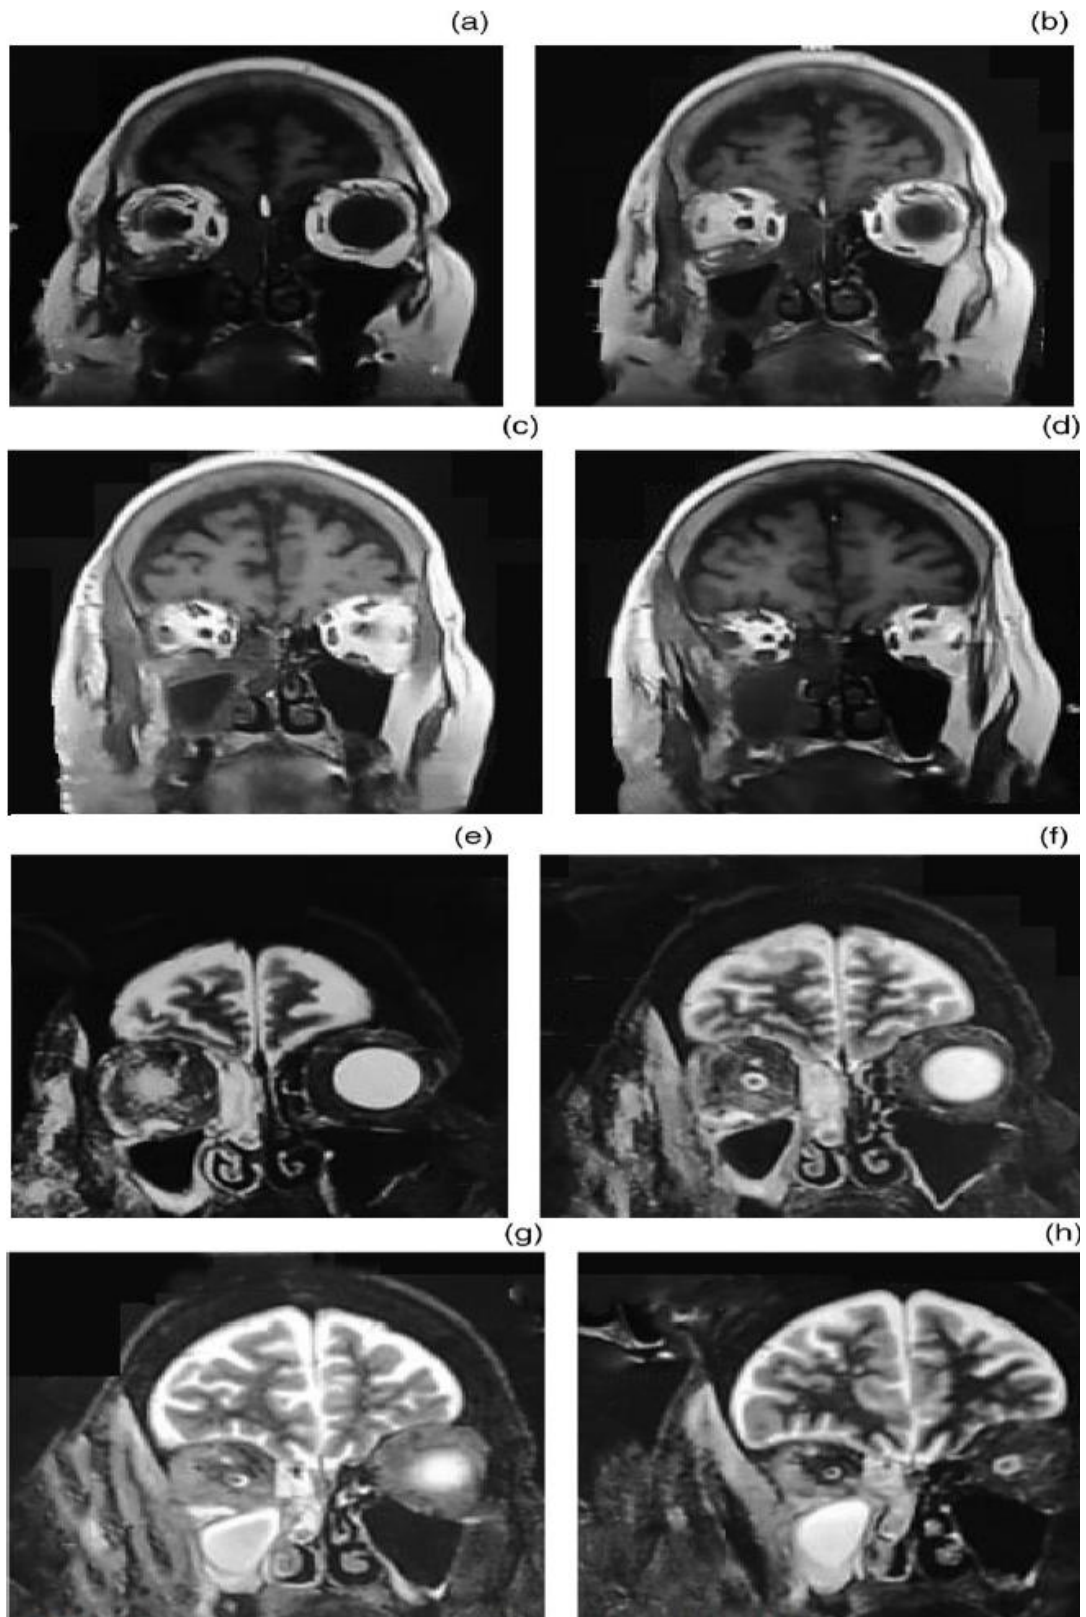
(a-h) Coronal, magnetic resonance imaging scans showing intra-orbital extension of mucormycosis.
